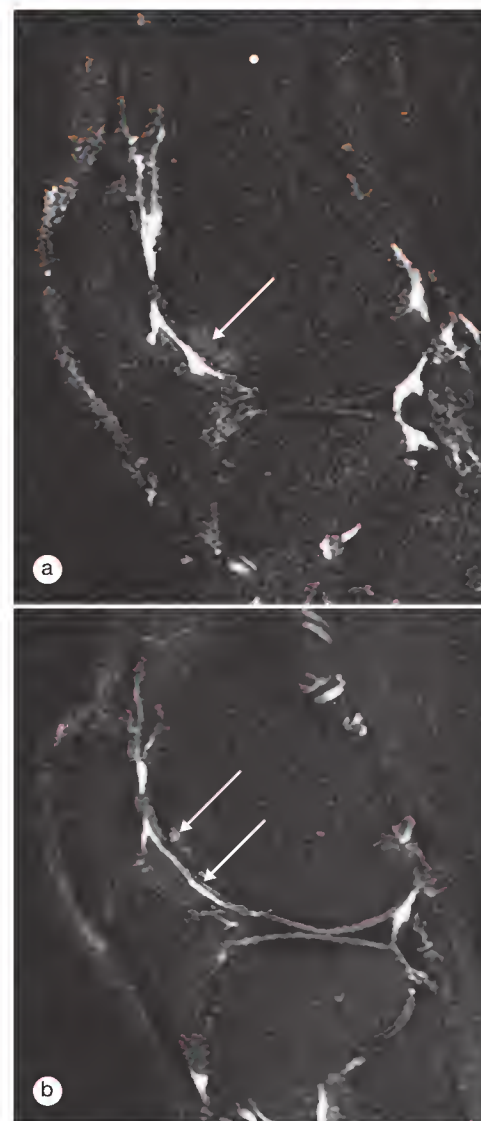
Sagittal T2-weighted fat-suppressed magnetic resonance images of the knee. (a) Bone marrow lesions (BMLs) with an edematous pattern (arrow) are apparent on the anterior lateral trochlea. (b) Image taken 6 months later shows that these lesions have become cystic in nature (arrows). Note also articular cartilage loss overlying the BMLs.
